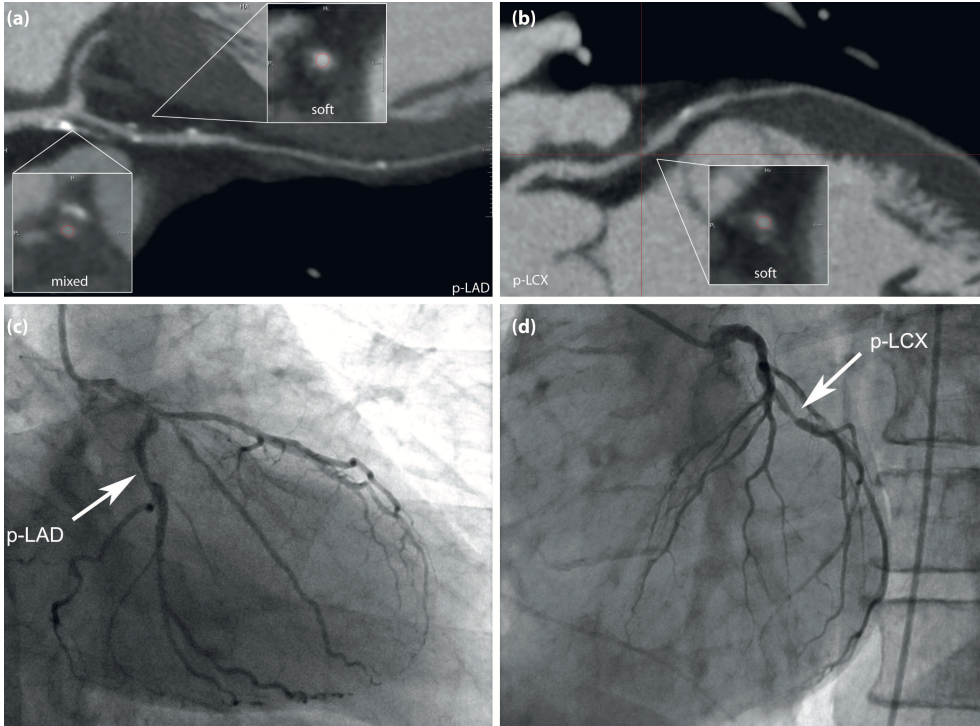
Example of patient 01 (61 y.o. male). The CTA report indicates only mild (20-50%) stenoses in the LAD (a) and one significant stenosis in p-LCX segment (suspected single-vessel disease) (b). The QCA analysis reveals a 46% stenosis in the proximal LAD coronary segment (c) and a 63% stenosis in the proximal LCX segment (d).
